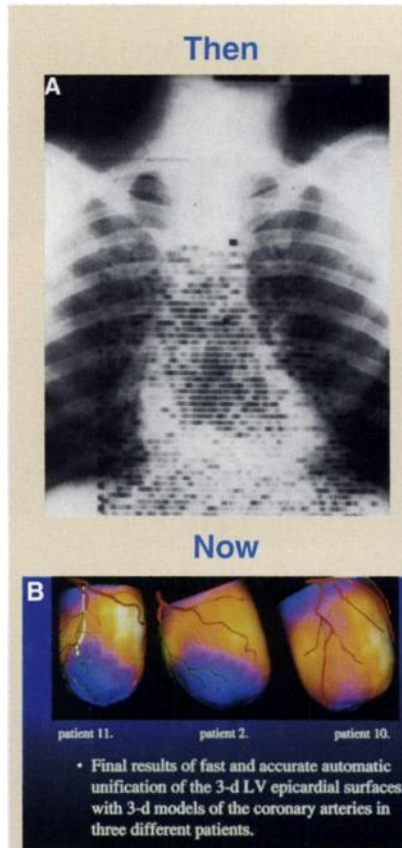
(A) Image from 40 years ago in which a chest radiograph was fused with an ¹³¹I human serum albumin rectilinear scan of the cardiac blood pool in a patient with a pericardial effusion. (B) Fused images from automated contrast angiogram and ²⁰¹Tl images of myocardial perfusion in patients with coronary perfusion defects correlated with angiographic evidence of coronary artery stenosis (Abstract no. 574).
